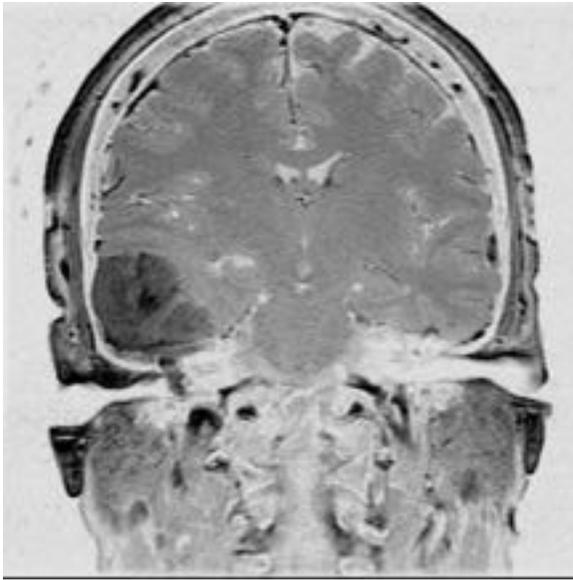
(continued) Middle fossa meningioma presenting with headache, tinnitus, and hearing loss. (C) Videonystagmography showing a 27% reduced right caloric response. (D) Coronal noncontrast computed tomography of the temporal bone through the cochlea. The right side shows hyperostosis along the tegmen not seen on the left side. (continued)
